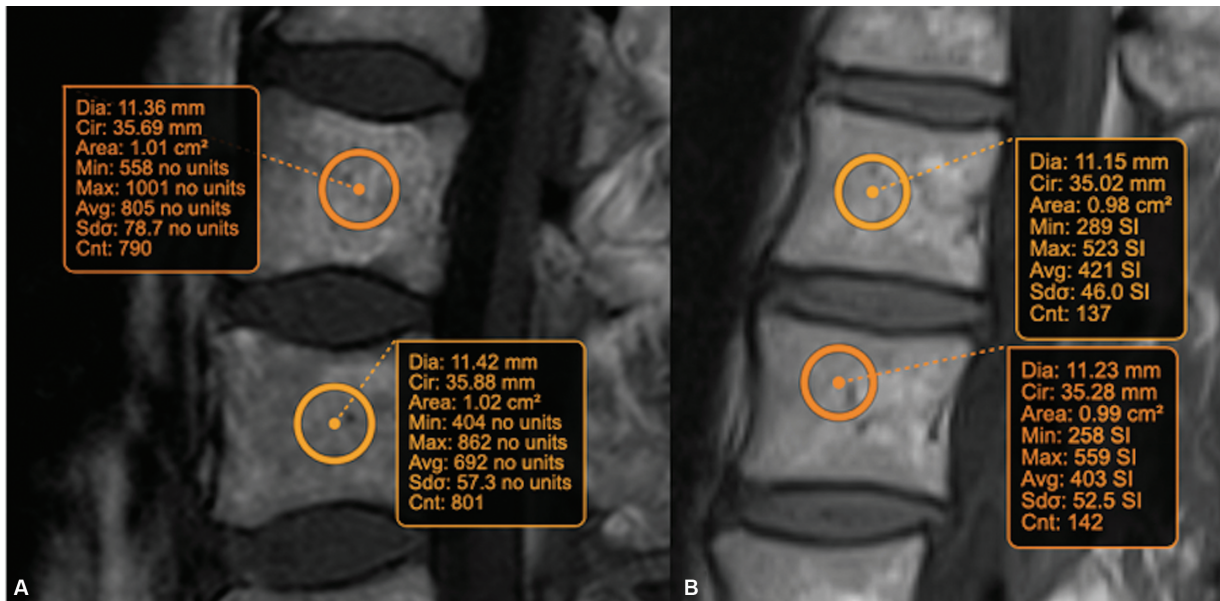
Sagittal T1-weighted images from the normal cohort showing calculation of T1 ratio of marrow (TROM) at L2/L3 level. TROM in patient (A) is 805/692 = 1.16 and that in patient (B) is 421/403 = 1.04.
